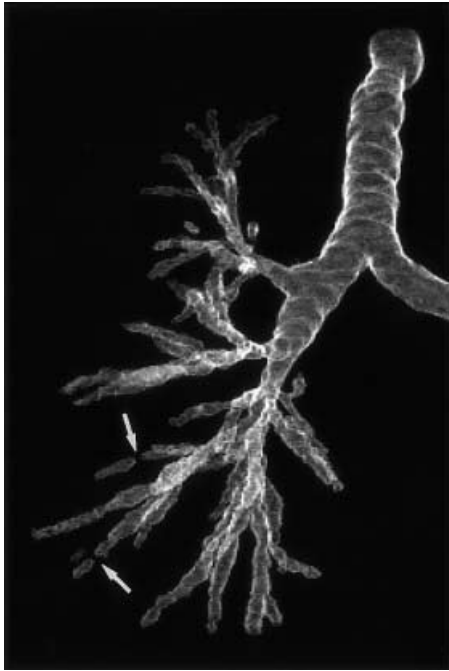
Bronchiectasis on a virtual bronchogram. Coronal view of virtual bronchography after multislice CT acquisition and thin slice thickness targeted on the right lung. Cylindrical bronchiectasis is seen involving several bronchi in the right middle and lower lobes. Irregularities in bronchial caliber are well displayed. Discontinuities in bronchial lumen (arrows) reflect the filling of bronchial lumen by retained secretions
